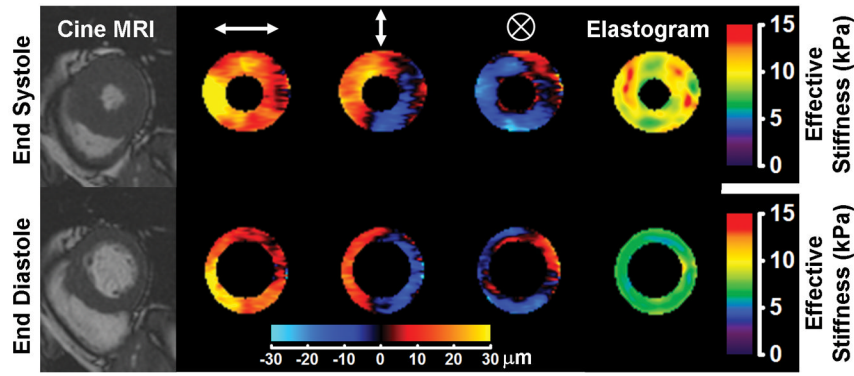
Cardiac MRE performed in a healthy volunteer as described in Kolipaka et al. (207). The subject was imaged in the supine position with 80-Hz vibrations induced in the heart via a pneumatic driver system placed against the chest wall anterior to the heart. Measurements were performed of the short axis of the left ventricle at the end of systole and the end of diastole. The left column shows MR images from a cine acquisition showing the anatomy of the left ventricle at these phases of the cardiac cycle. Columns 2, 3, and 4 show masked wave images of the horizontal, vertical, and through-plane components of the motion, respectively, produced in the heart. Column 5 shows the elastograms produced from the wave data. The cardiac tissue can be seen to be significantly stiffer at the end of systole than at the end of diastole. (Courtesy of Dr. Arunark Kolipaka, The Ohio State University Medical Center, Columbus, OH.)
